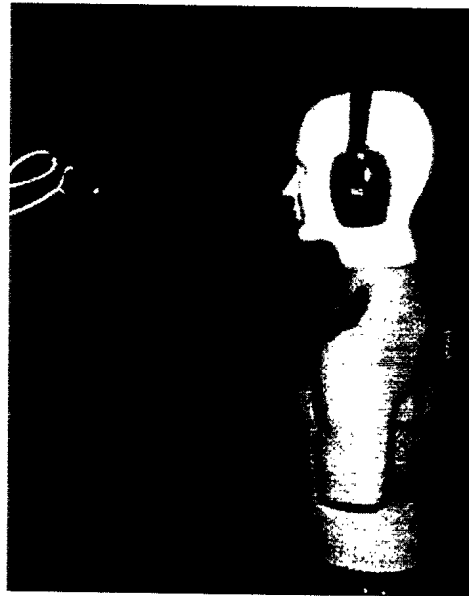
Relationship of ATF and ultrasound source for grazing-incidence measurements.
